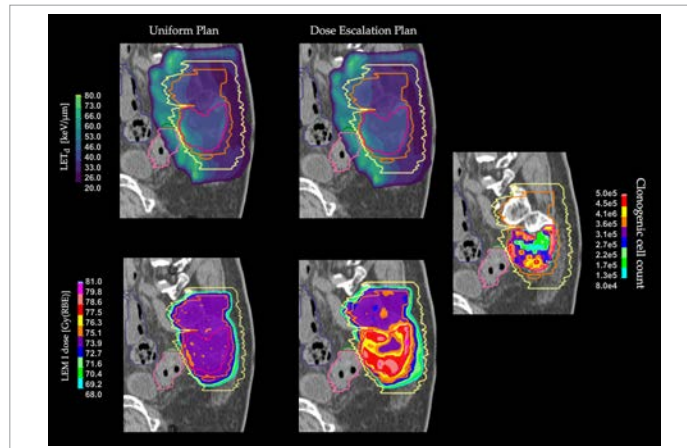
Comparison of effective dose and dose-averaged linear energy transfer maps from a conventional uniform-dose plan (left), and a biologically-guided dose escalation plan (center). On the right, the clonogenic cell count map estimated from diffusion-weighted magnetic resonance imaging. Overlaid in yellow and orange the low- and high- risk clinical target volumes, in red the gross tumor volume, in pink the sigma. LEM-I = Local effect model.
